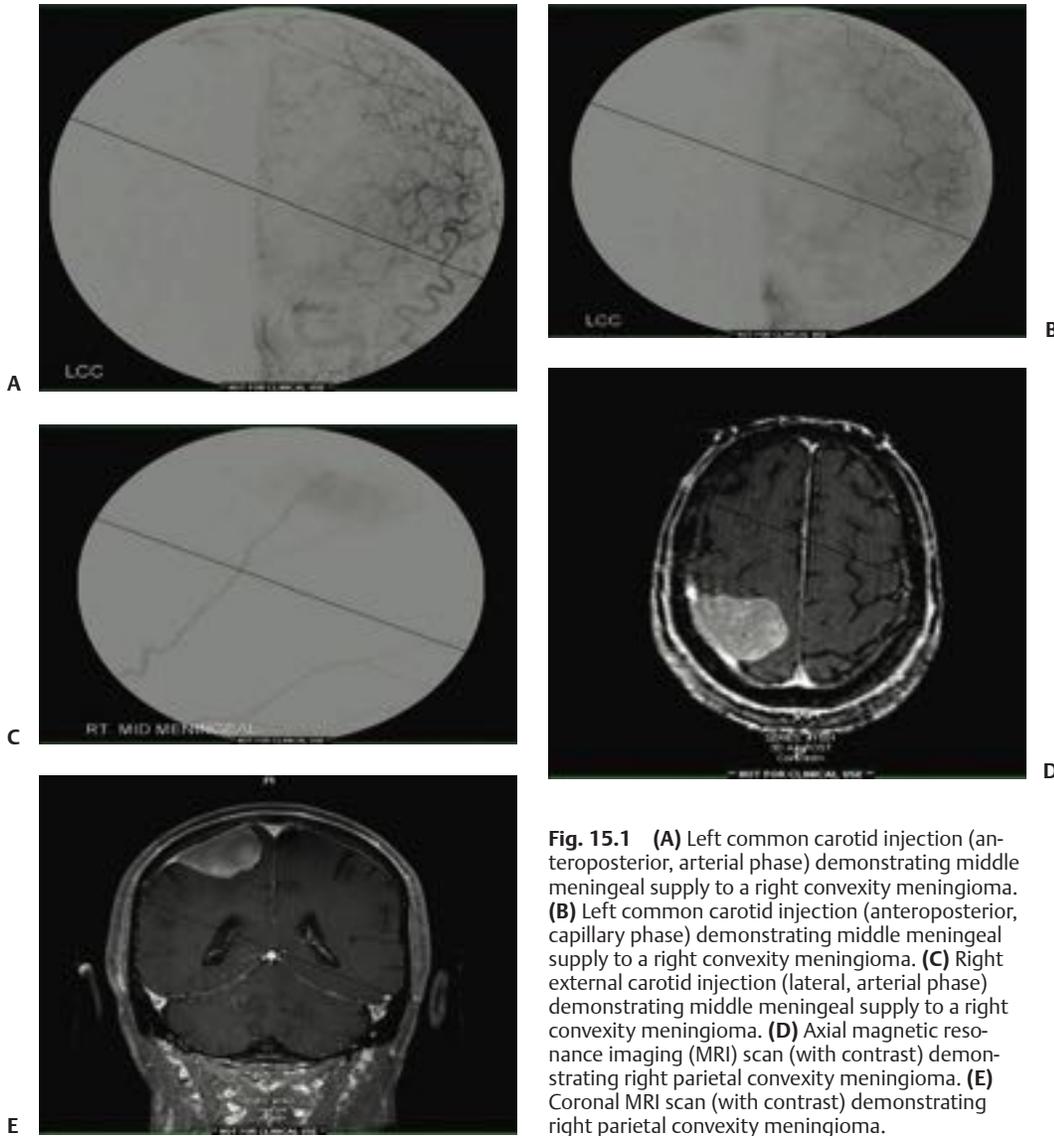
(A) Left common carotid injection (anteroposterior, arterial phase) demonstrating middle meningeal supply to a right convexity meningioma. (B) Left common carotid injection (anteroposterior, capillary phase) demonstrating middle meningeal supply to a right convexity meningioma. (C) Right external carotid injection (lateral, arterial phase) demonstrating middle meningeal supply to a right convexity meningioma. (D) Axial magnetic resonance imaging (MRI) scan (with contrast) demonstrating right parietal convexity meningioma. (E) Coronal MRI scan (with contrast) demonstrating right parietal convexity meningioma.
